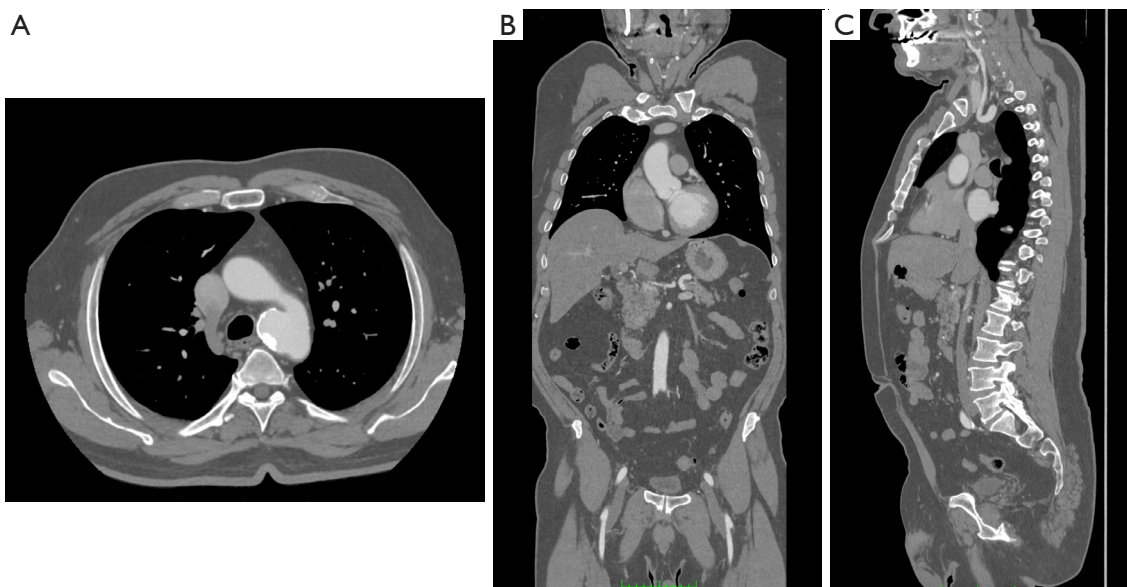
Axial (A), coronal (B), and sagittal (C) view of angio-CT. CT, computed tomography.
